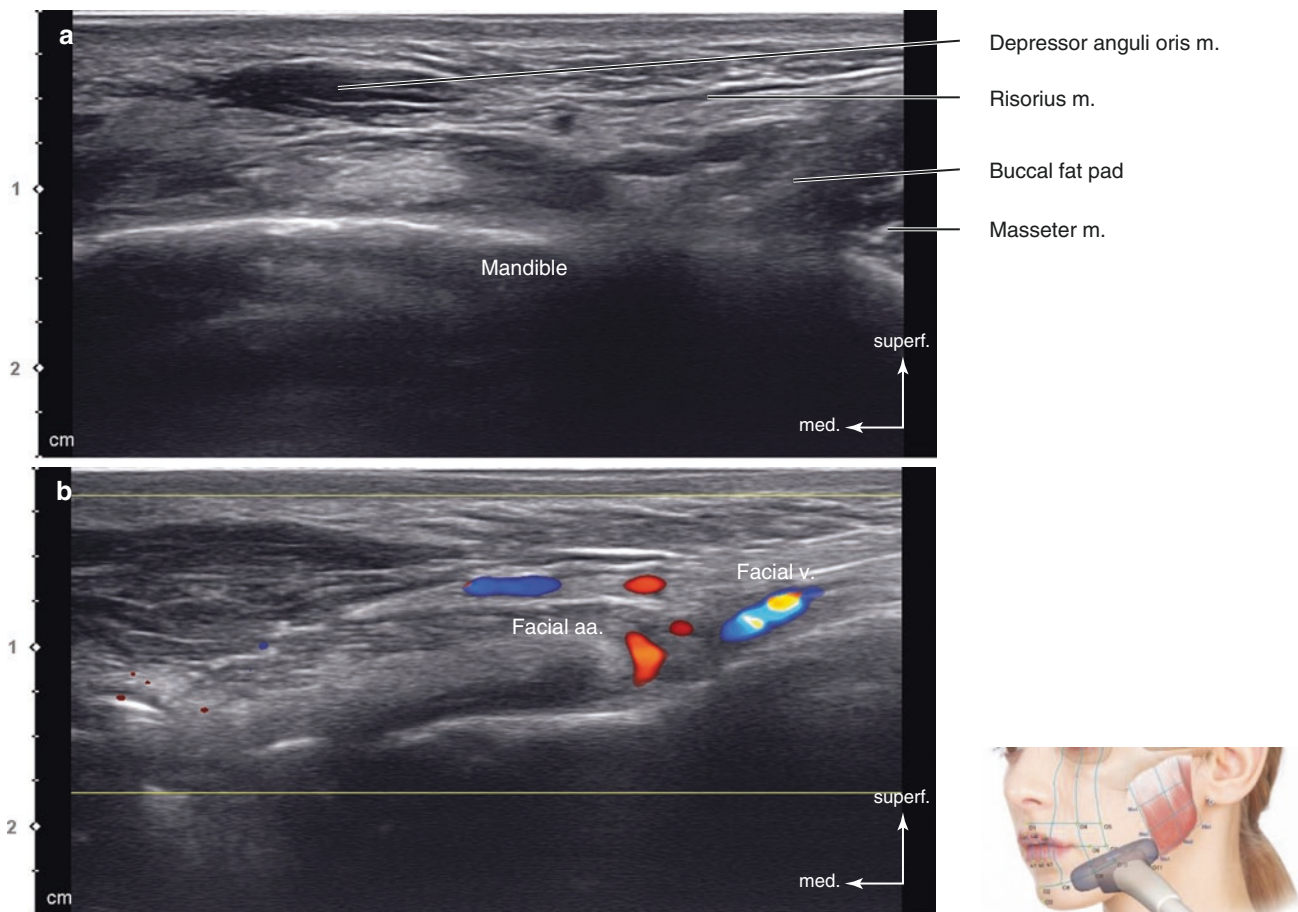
Ultrasonography of the intersection point of TL8 and PL3 (O10). (a) B mode (transverse view, 15 MHz by linear transducer) and (b) Doppler mode (transverse view, 15 MHz by linear transducer). (Published with kind permission of © Hee-Jin Kim 2020. All Rights Reserved)
